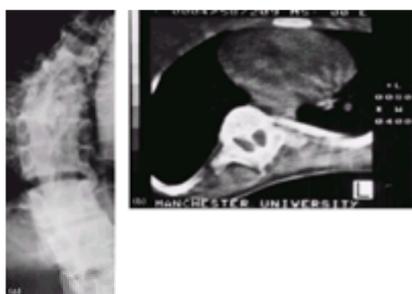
(a) Patient with congenital scoliosis. A bony spur can just be made out in the centre of the scoliotic segment. (b) CT scan showing the diastematomyelia. This patient had a complete bony spur dividing the spinal canal into two. The diastematomyelia may produce neurological symptoms. Traction on the spinal cord during elective surgery for scoliosis can produce paraplegia and, if a patient has a diastematomyelia, the spur must be resected prior to embarking upon scoliotic corrective surgery.
